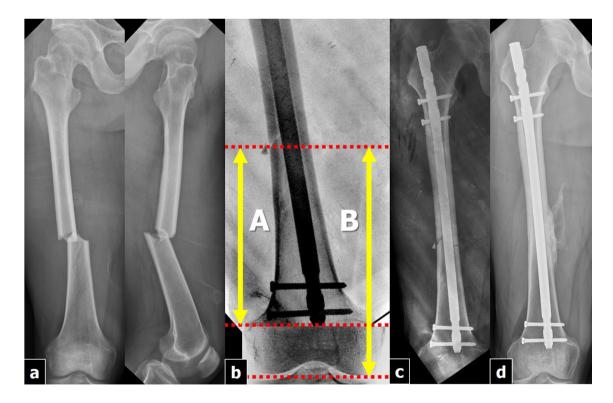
a 52-year-old man sustained an AO/OTA type A3 femoral shaft fracture. b Calculated EWLD was 0.8. c Antegrade nailing was performed in standard fashion. d Radiograph obtained after 18 months shows solid union of the fracture
